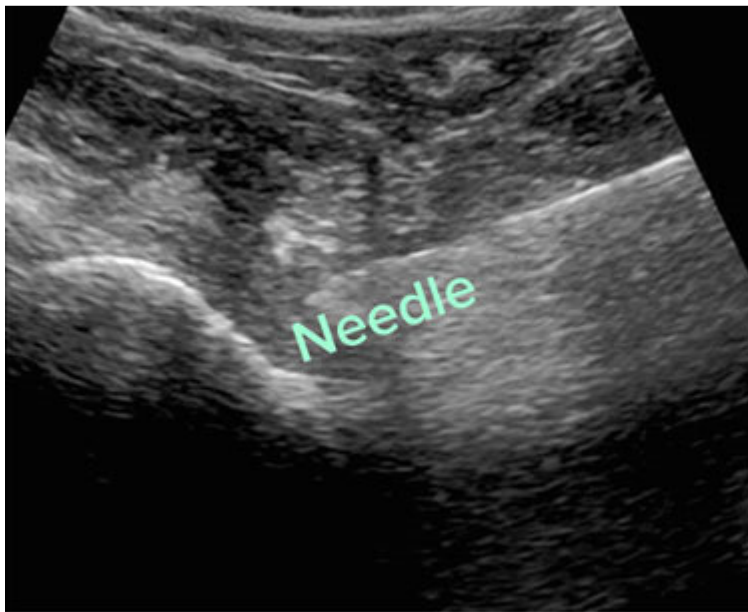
Real-time ultrasound of a hip injection, with the needle penetrating the hip joint
